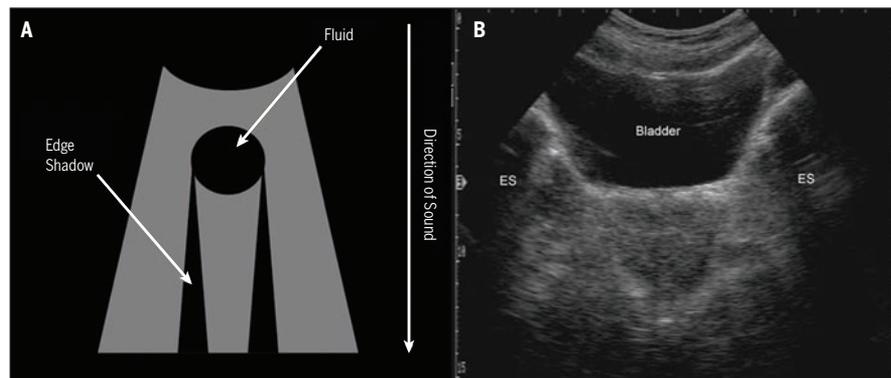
(A) Depiction of an edge shadow produced when a sound wave is refracted (bent) around the edges of a fluid-filled structure. (B) A transverse ultrasound image demonstrating edge shadowing (ES) caused by the bladder. Reproduced with permission Whittaker 2007.¹⁴²
